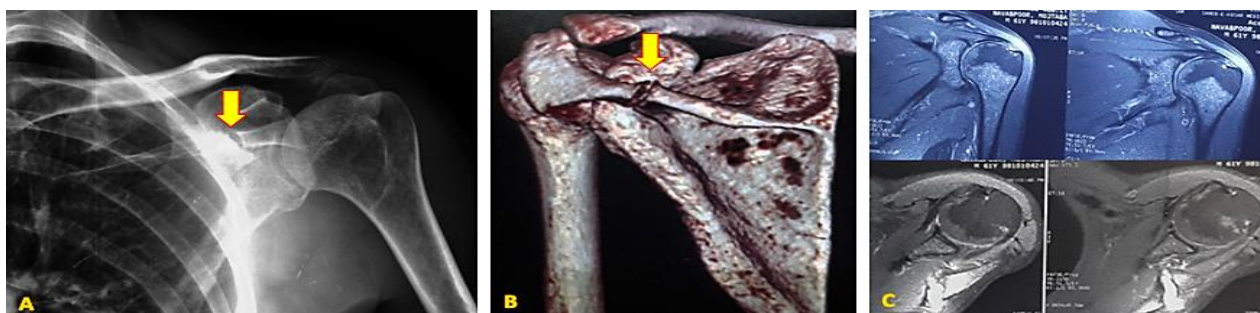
A: Plain X-ray, B: 3-dimensional computed tomography (3D-CT) scan, C: magnetic resonance imaging (MRI) (Yellow arrow indicates fracture site and the red arrow indicates rotator cuff tear)
